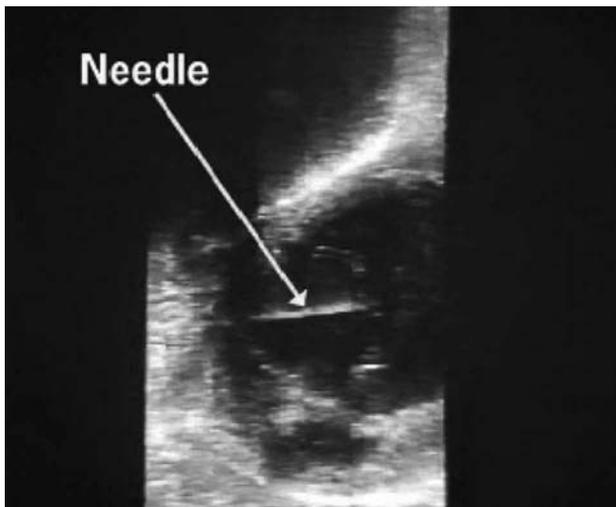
Transrectal ultrasonography, Arrow demonstrates the needle.
